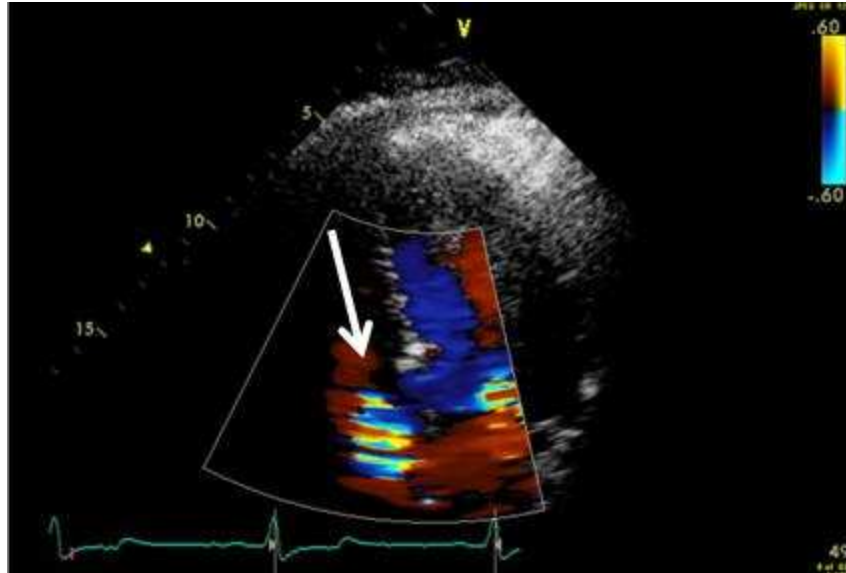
Color flow Doppler display of tricuspid valve regurgitation (Sorrell and Kumar 2011). The arrow indicates backward flow
